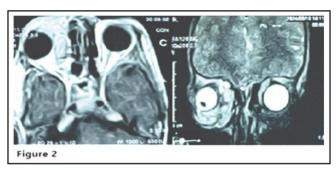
Orbital MRI T1 and T2 weighted showing a diffuse heterogeneous, non-encapsulated, multilocular, poorly defined cystic lesion in the right orbit with multiple air-fluid levels.
